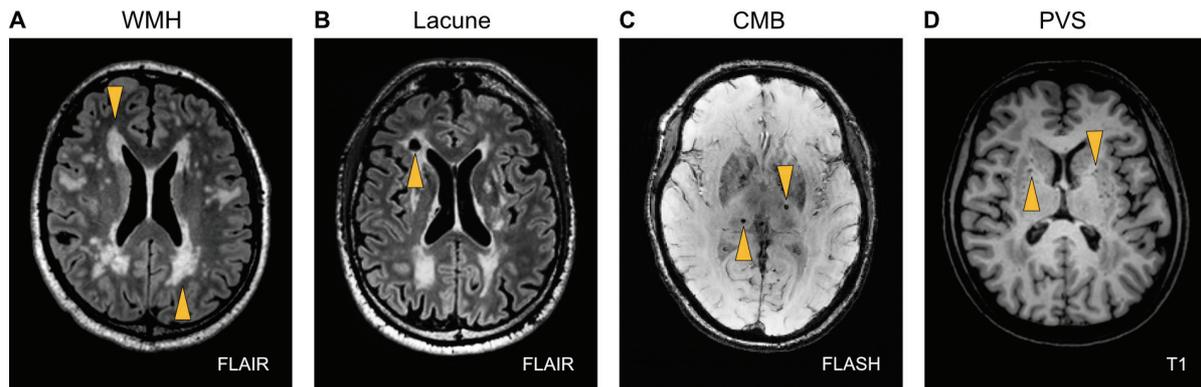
Total cerebral small vessel disease score. The total SVD score summarizes the severity or presence of the following conventional MRI markers of SVD on an ordinal scale from 0 to 4 (Staals *et al.*, 2014): (A) WMH burden on Fazekas scale 2-3 (1 point), (B) at least one lacune (1 point), (C) at least one CMB (1 point), and (D) more than 10 PVS in the basal ganglia on a single T1-weighted axial image slice with the highest number of enlarged perivascular spaces (1 point). Abbreviations: CMB = cerebral microbleed; FLASH = fast low angle shot; FLAIR = fluid-attenuated inversion recovery; PVS = enlarged perivascular spaces; WMH = white matter hyperintensity.
